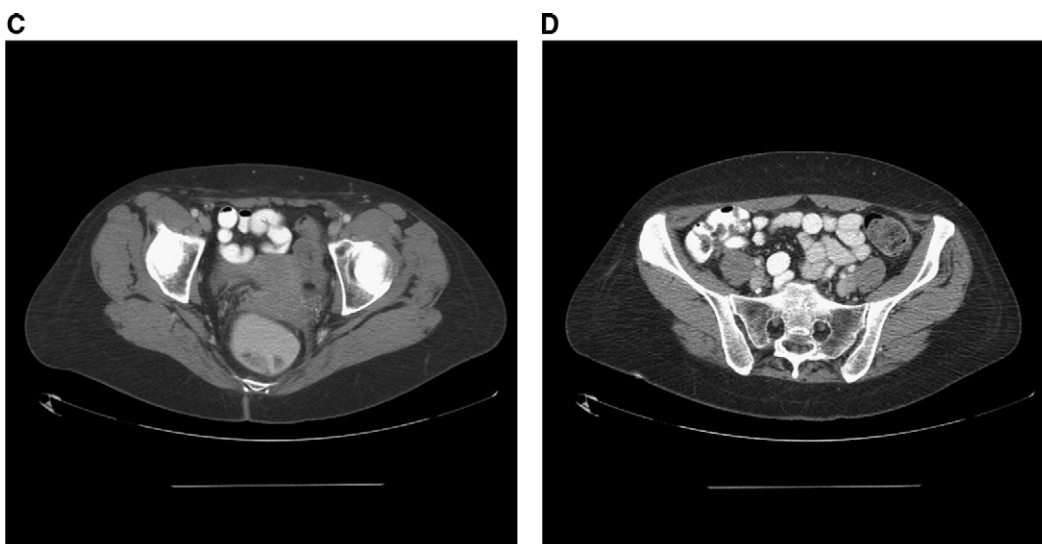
After neoadjuvant therapy, a computed tomographic scan shows that the previously noted pelvic mass had significantly decreased in size (C) and the omental disease was no longer visible (D).
